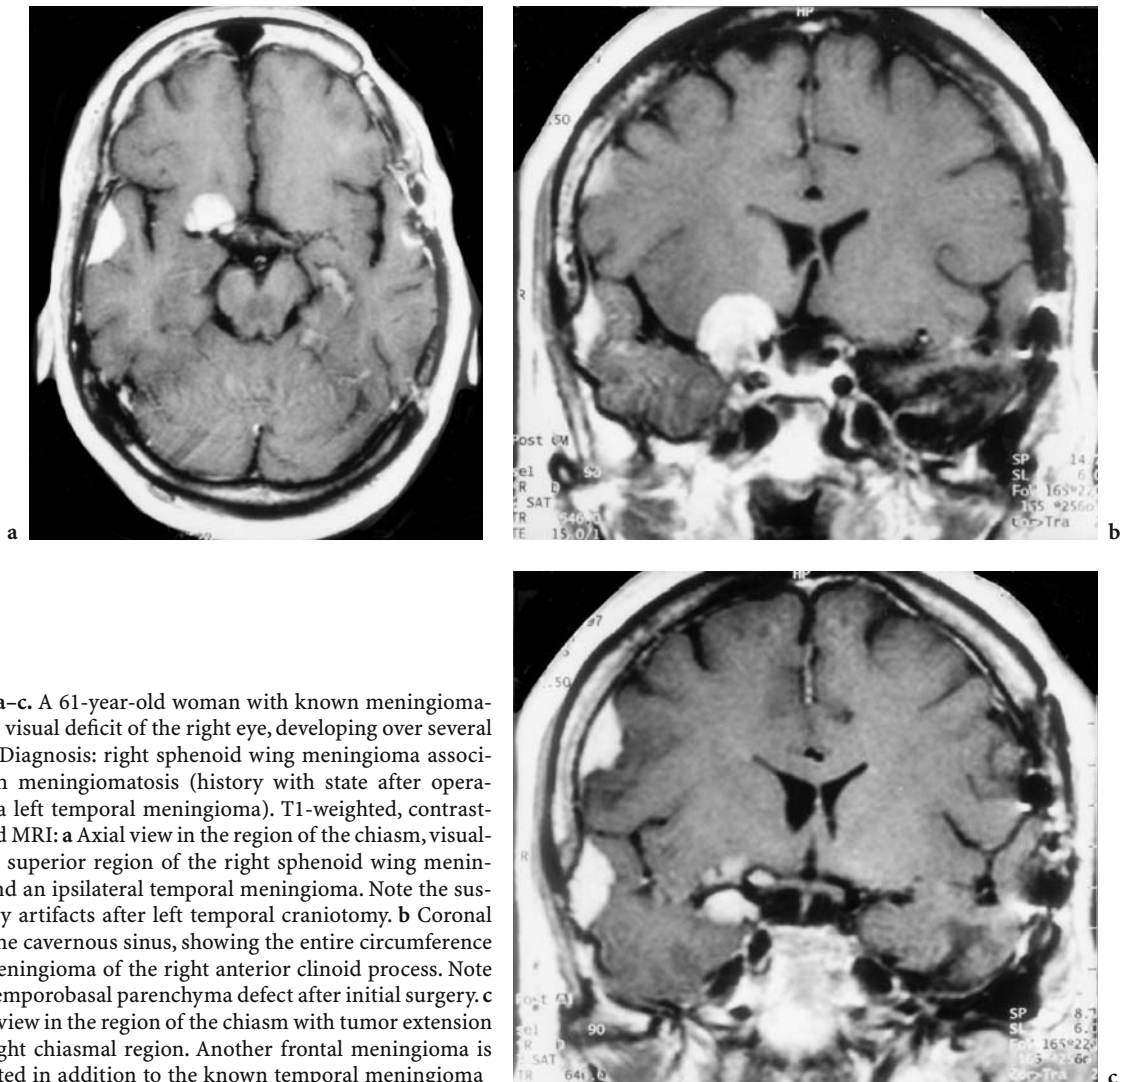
A 61-year-old woman with known meningiomatosis and visual deficit of the right eye, developing over several months. Diagnosis: right sphenoid wing meningioma associated with meningiomatosis (history with state after operation for a left temporal meningioma). T1-weighted, contrast-enhanced MRI: a Axial view in the region of the chiasm, visualizing the superior region of the right sphenoid wing meningioma and an ipsilateral temporal meningioma. Note the susceptibility artifacts after left temporal craniotomy. b Coronal view at the cavernous sinus, showing the entire circumference of the meningioma of the right anterior clinoid process. Note the left temporobasal parenchyma defect after initial surgery. c Coronal view in the region of the chiasm with tumor extension to the right chiasmal region. Another frontal meningioma is demarcated in addition to the known temporal meningioma
